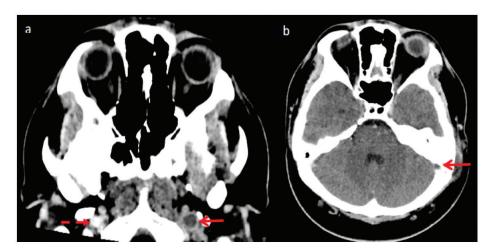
Transverse contrast-enhanced CT Brain shows (a) Left IJV complete luminal occlusion by low attenuation thrombus with rim enhancement (solid arrow) as compared to the normally opacified right IJV (dashed arrow). (b) Left partial sigmoid sinus thrombosis.
